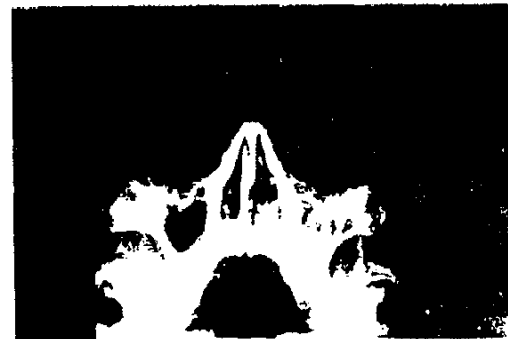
Plain X-ray of patient No. 3 showing two very high attenuated densities in the left maxillary sinus (non-invasive).
